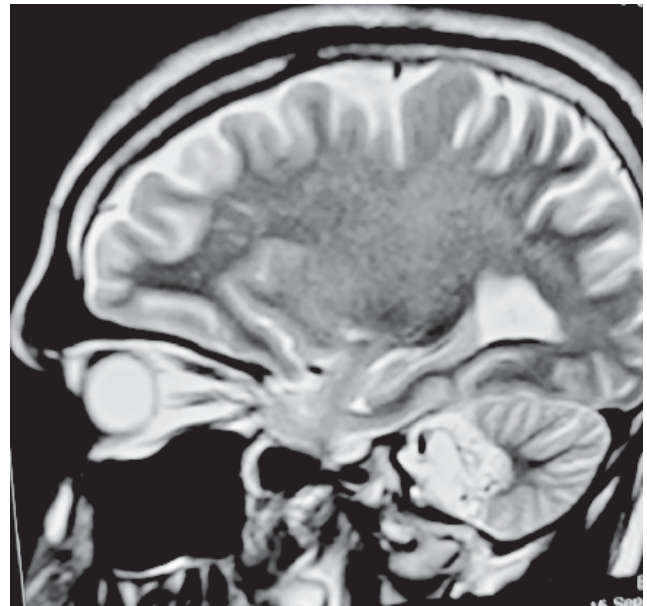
Sagittal T2 weighted MR image.
